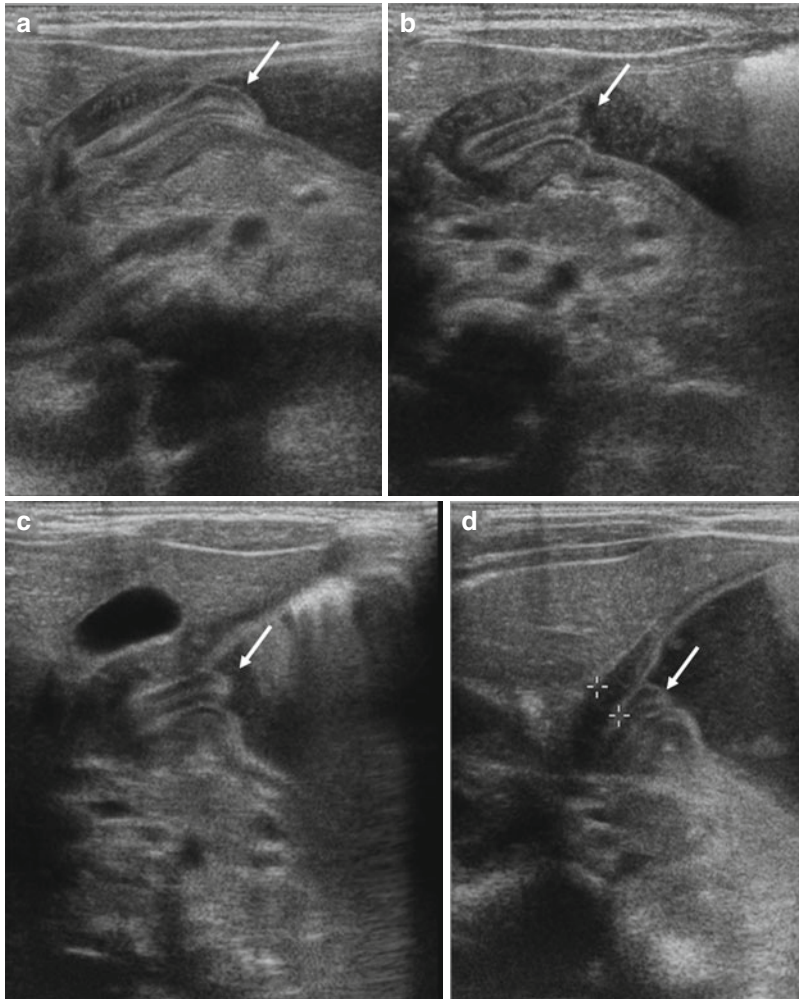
(a–d) Child, 5 weeks. Ultrasound shows “cervix” sign (*white arrow*): prolapse of the pyloric canal mucosa into the fluid-filled antrum
